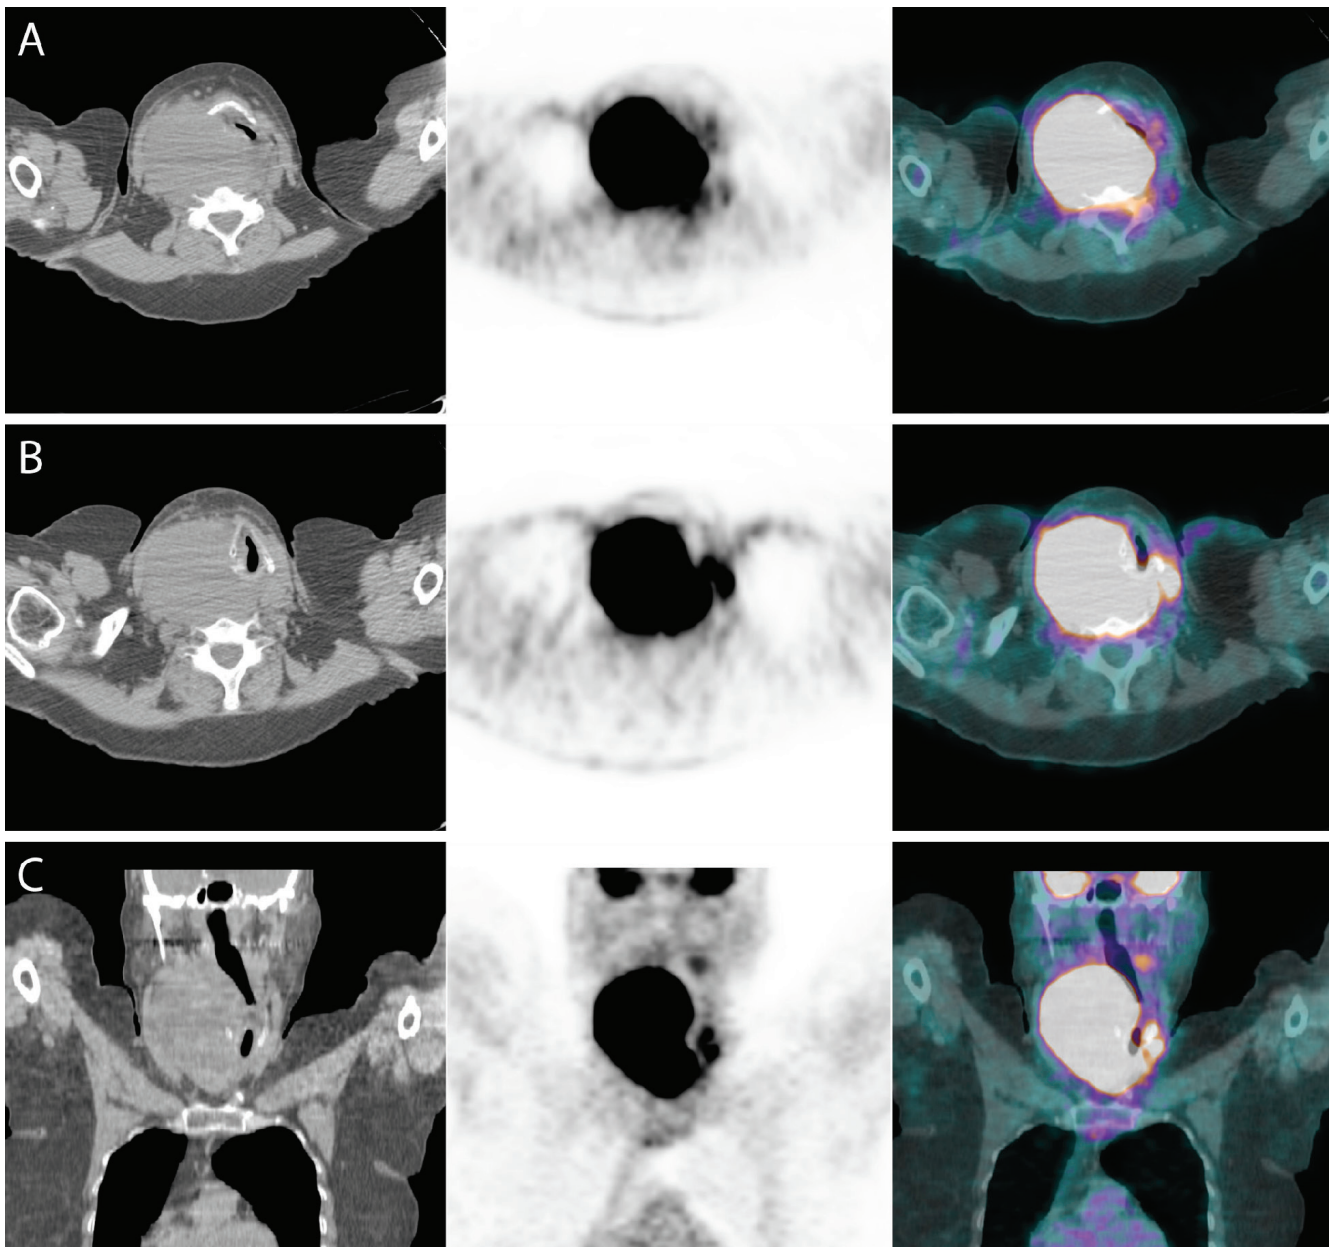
(A, B) Transaxial and (C) coronal views of the neck with CT (left), PET (middle), and PET/CT fusion (right) images show right thyroid DLBCL, measuring 13x9 cm with maximum standardized uptake value (SUV_{max}) 54, compressing the trachea to a narrow slit left of the midline.
